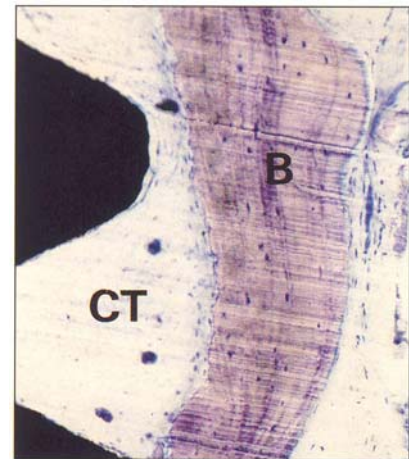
Magnification of Fig 8-10a, showing formation of lamellar bone (B) at a distance from the implant surface. (CT) Fibrous connective tissue.
